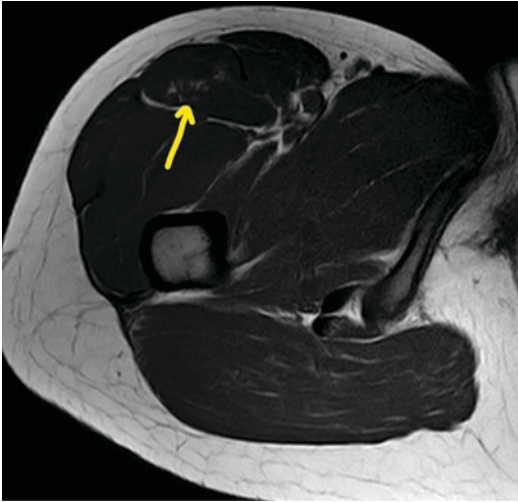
MRI of upper thigh of professional women's tennis player demonstrating an acute Rectus Femoris Strain. (Image used with permission from Marc R. Safran, MD)
